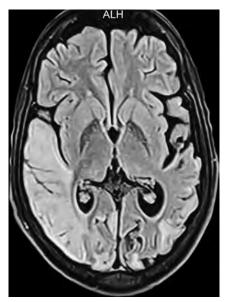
T2-weighted hyperintensities in bilateral parieto-occipital lobes
